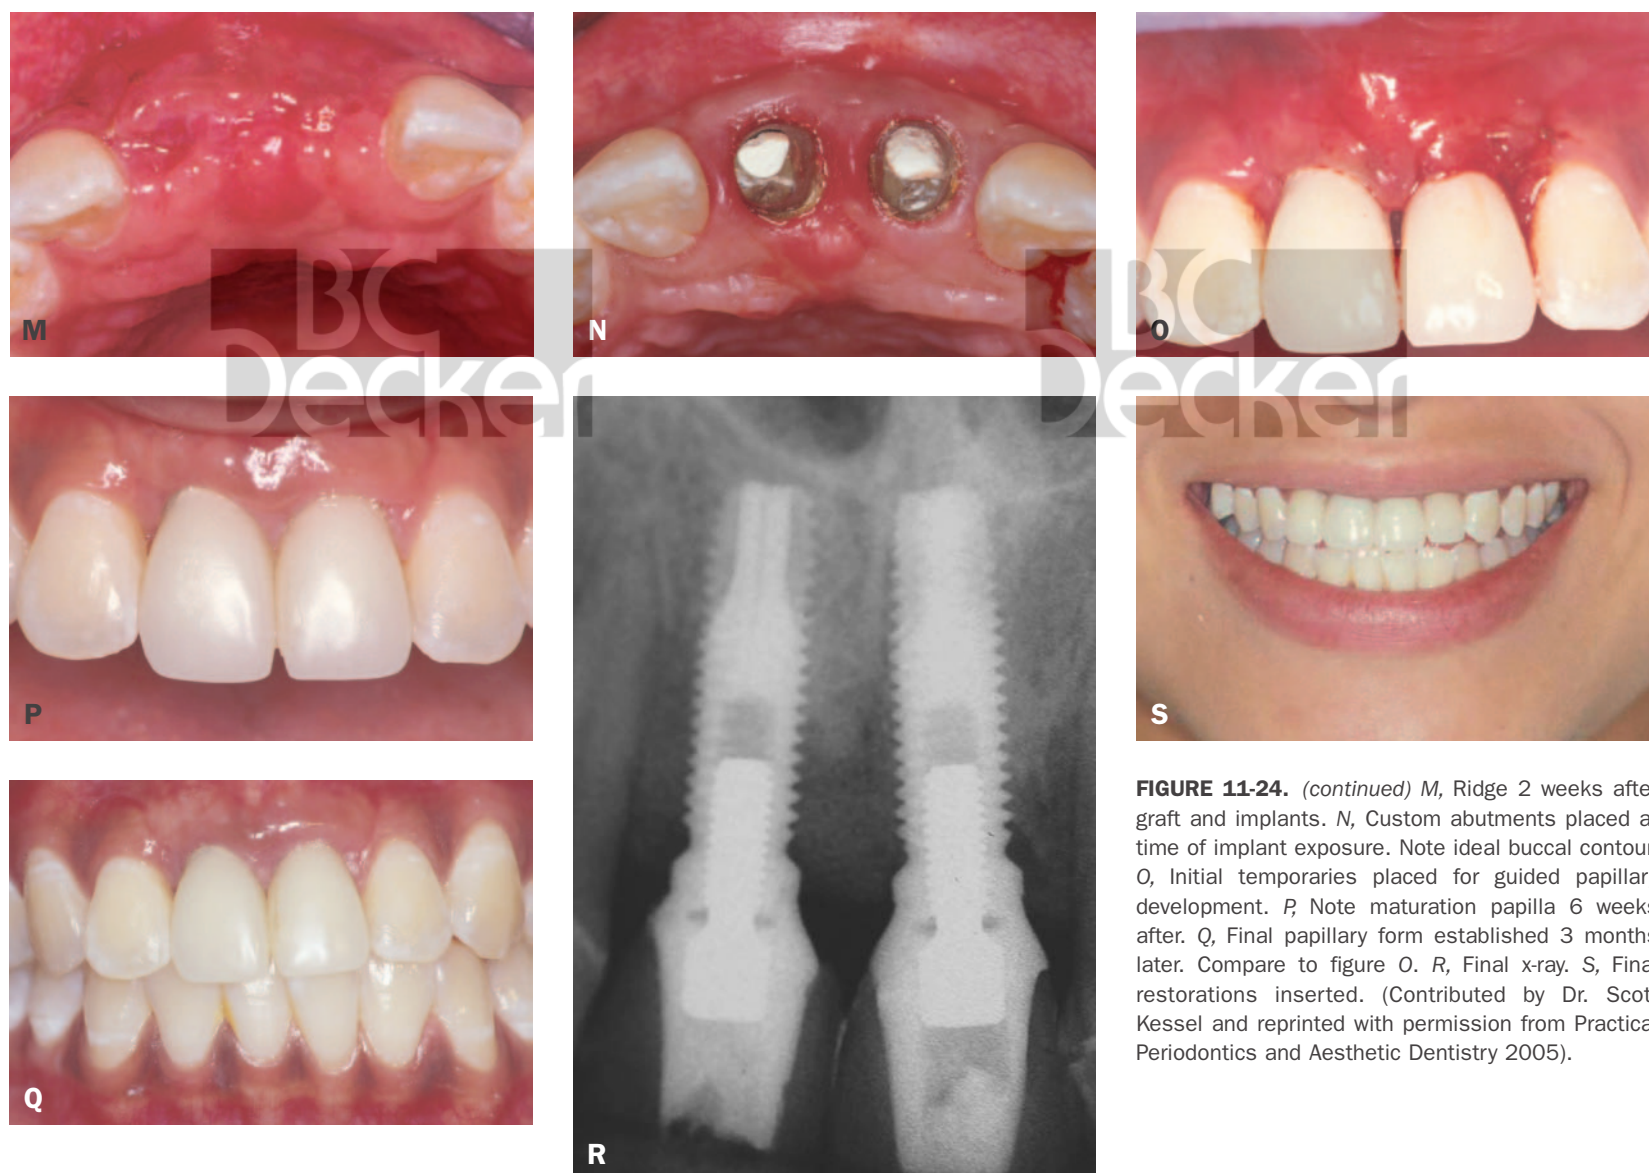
(continued) M, Ridge 2 weeks after graft and implants. N, Custom abutments placed at time of implant exposure. Note ideal buccal contour. O, Initial temporaries placed for guided papillary development. P, Note maturation papilla 6 weeks after. Q, Final papillary form established 3 months later. Compare to figure O. R, Final x-ray. S, Final restorations inserted. (Contributed by Dr. Scott Kessel and reprinted with permission from Practical Periodontics and Aesthetic Dentistry 2005).
